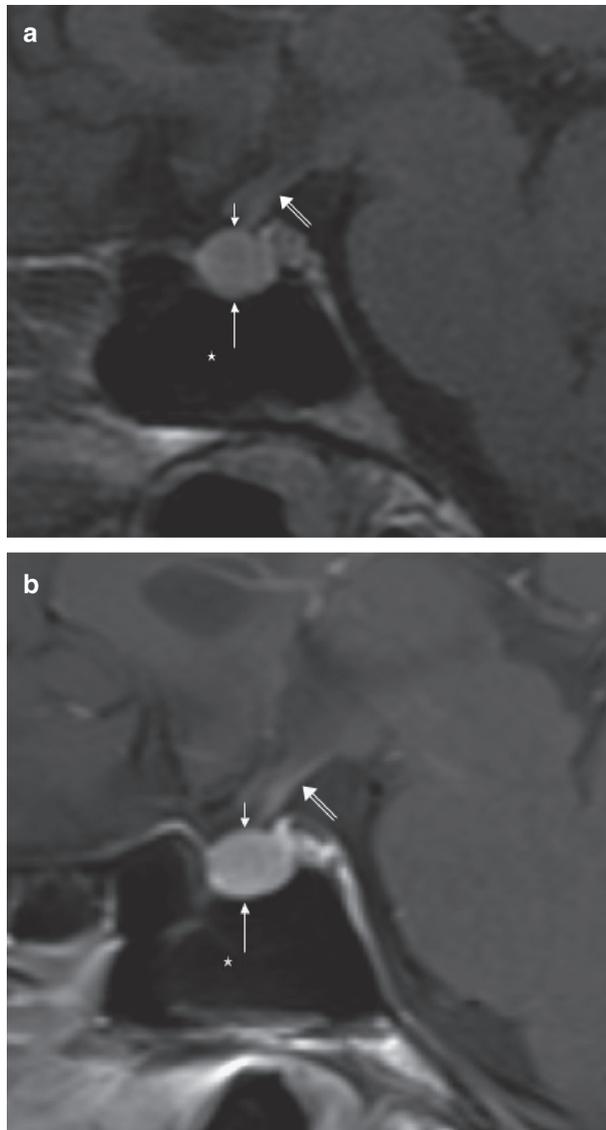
MRI of the sellar region. Sagittal contrast enhanced T1 weighted image at the initial scan (a) and at the 3-month follow-up (b). Note the diffuse and strong contrast enhancement of the enlarged pituitary gland. The short arrow points at the superiorly convex margin of the adenohypophysis, the long arrow at the sellar floor, the open arrow at the pituitary stalk. The asterisk marks the air filled sphenoid sinus.
